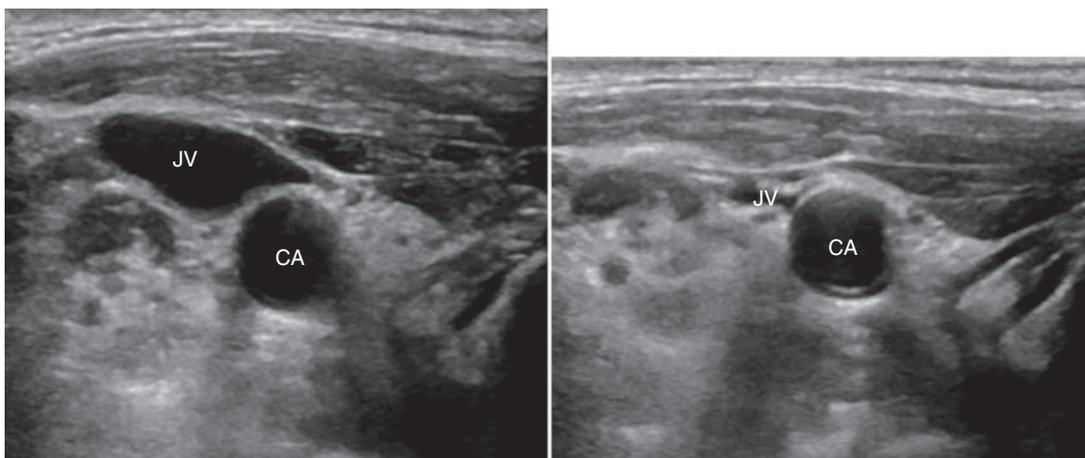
Two ultrasound images of the right internal jugular vein (JV) and right carotid artery (CA). In the first image, the jugular vein is distended; in the second image, the jugular vein is collapsed by gently applying pressure with the ultrasound transducer. The carotid artery did not compress.
